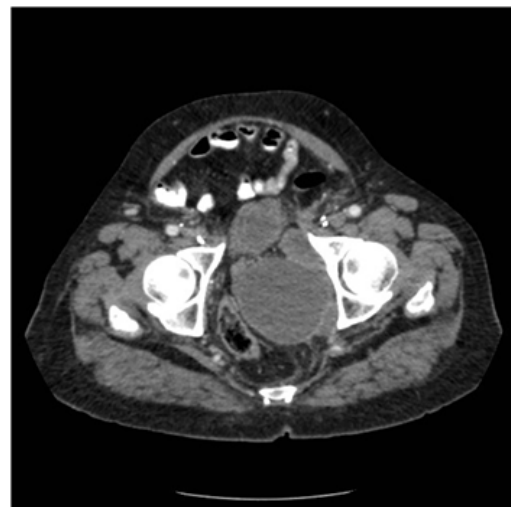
CT-Scan showing pre-sacral cystic lesion.
